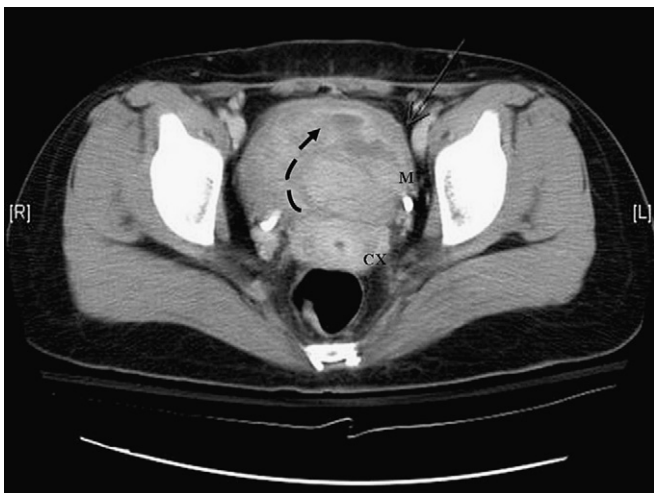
The computed tomography showed a 5 × 6 × 9 cm exophytic tumor (M) in lower anterior aspect of lower uterine corpus with central fluid accumulation and connection to uterine cavity (arrow) just above the bladder.
